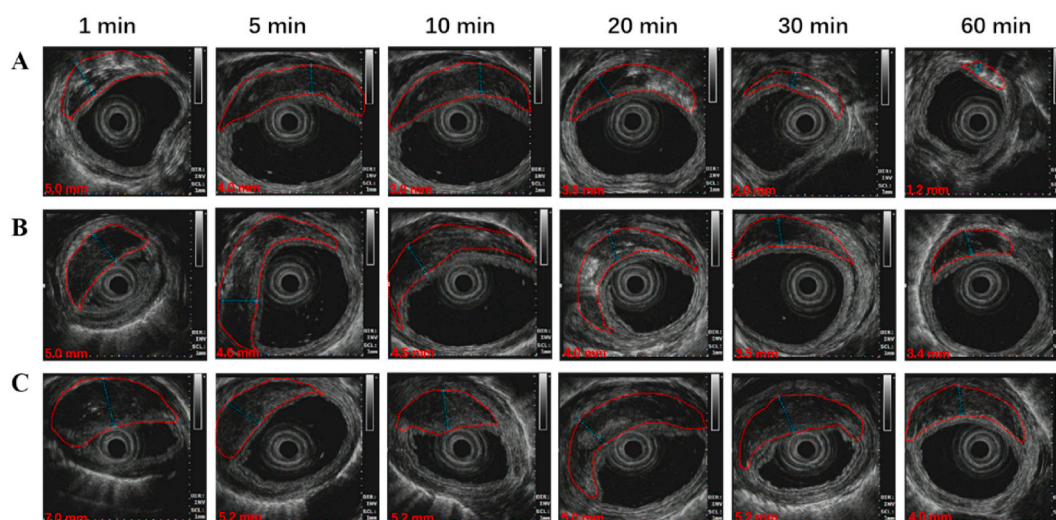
Endoscopic ultrasonography (EUS) images of the submucosal liquid cushions of NS (A), GO1 (B) and GO2 (C) at different time points (1, 5, 10, 20, 30, 60 min). The G-OALG position was marked with red circle.
